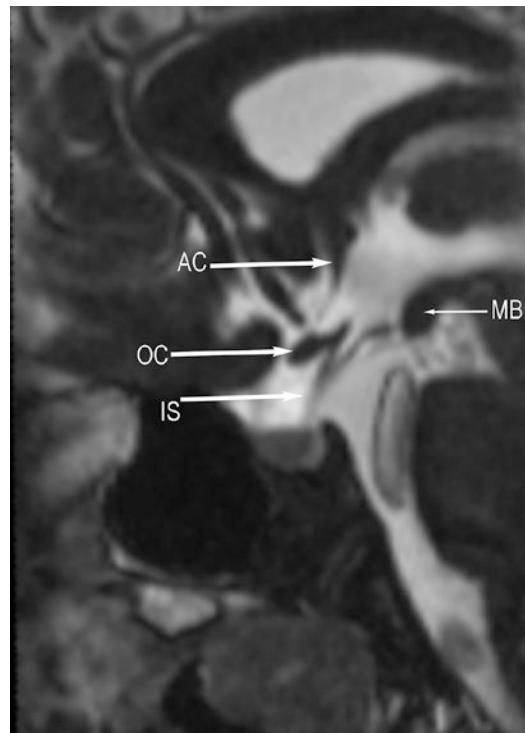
MR anatomy* of boundaries of the hypothalamus on high-resolution sagittal T2-weighted image. IS infundibulum stalk, OC optic chiasm, AC anterior commissure, MB mammillary bodies
